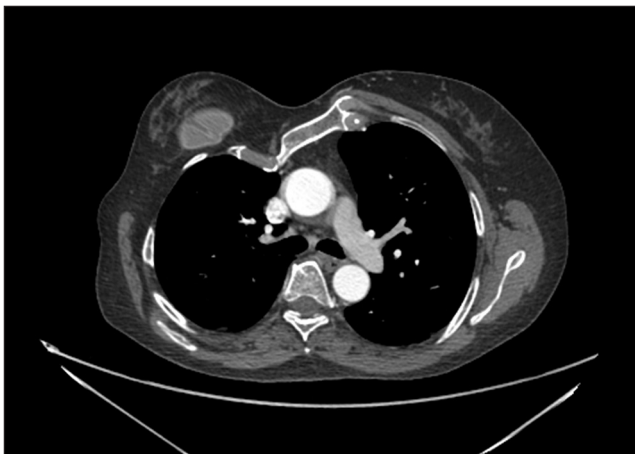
Computed tomography angiography of the chest shows a 2A1 pectus excavatum chest wall deformity according to Park's classification, as well as a hypoplastic appearance and a substernal displacement of the internal mammary vessels
